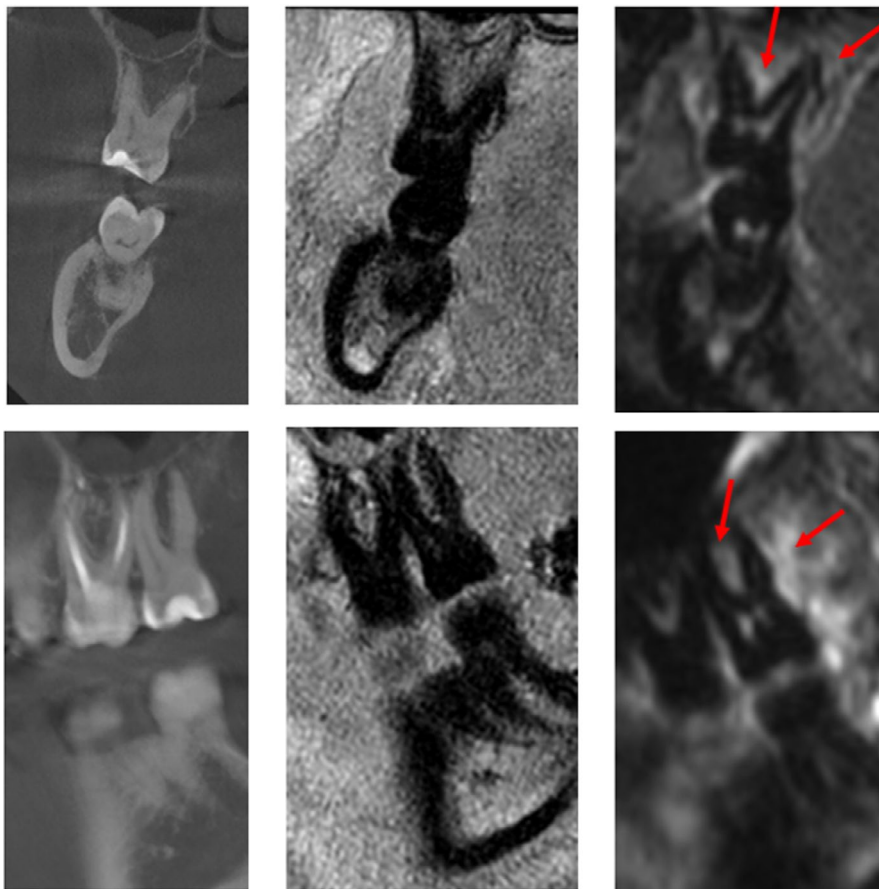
Comparison of CBCT, 3D T1 Black bone sequence and STIR sequence (left to right). Red arrows show osseous oedema in the area of the furcation and adjacent to the distal root which can solely be delineated in the STIR sequence
